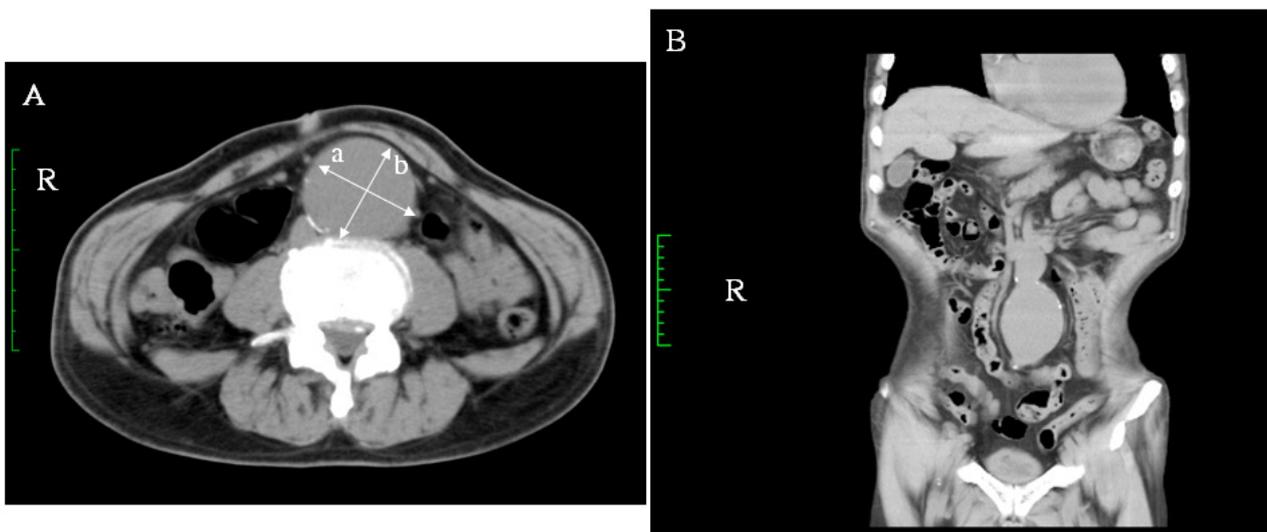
Axial (A) and coronal (B) plain CT images at the abdominal level in Case 2.
